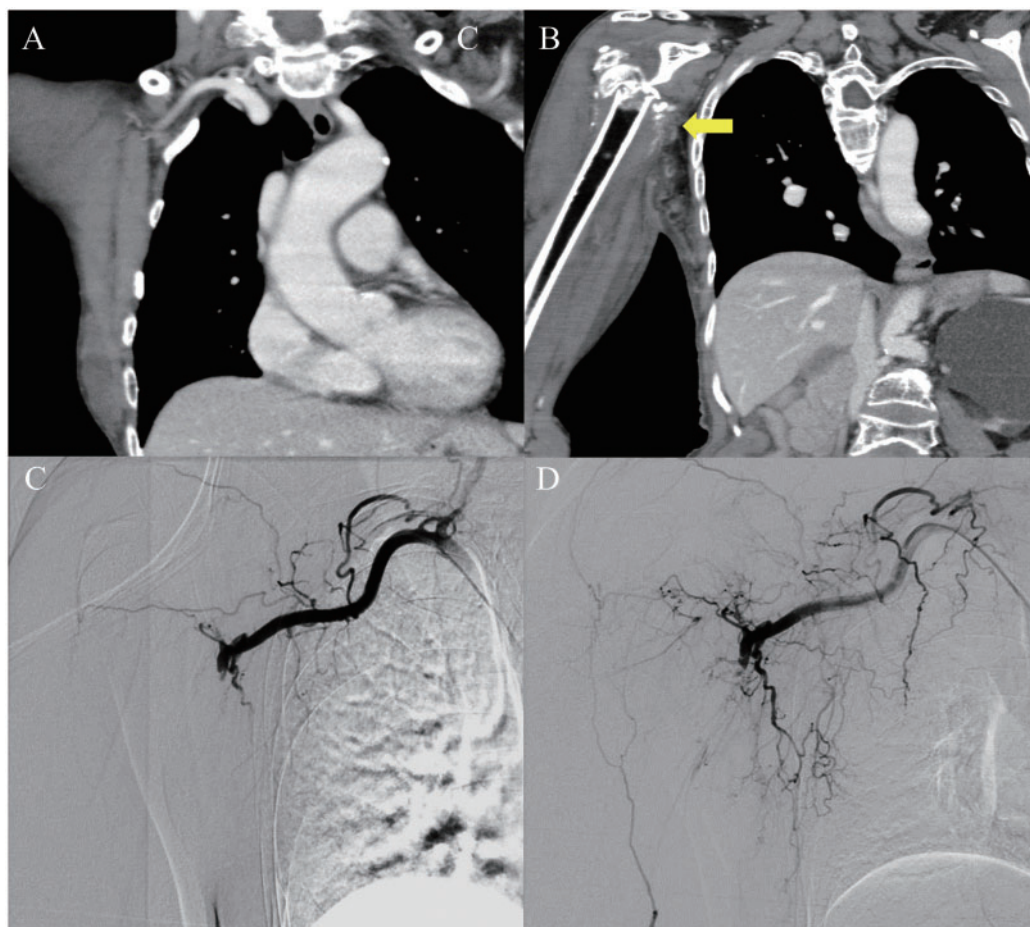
Computed tomography angiography showing disruption of the right axillary artery (A) and contrast medium extravasation from the right axillary artery (B). Right subclavian angiogram showing occlusion of the right axillary artery (C) and contrast-enhanced visualization of the right brachial artery via collateral flow (D).
